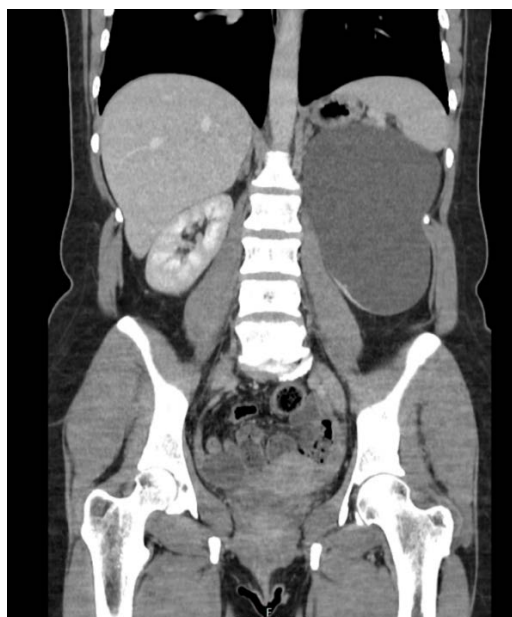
Longitudinal section CT image observation left kidney cyst.
